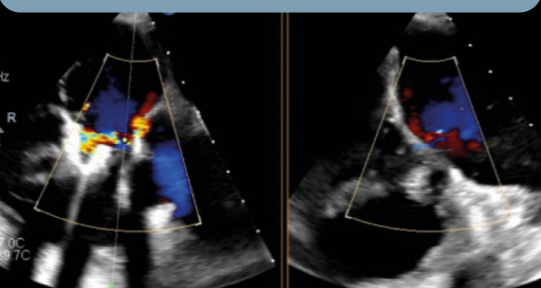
Transoesophageal echocardiograms before, during and after device implantation using the PASCAL Precision system.
